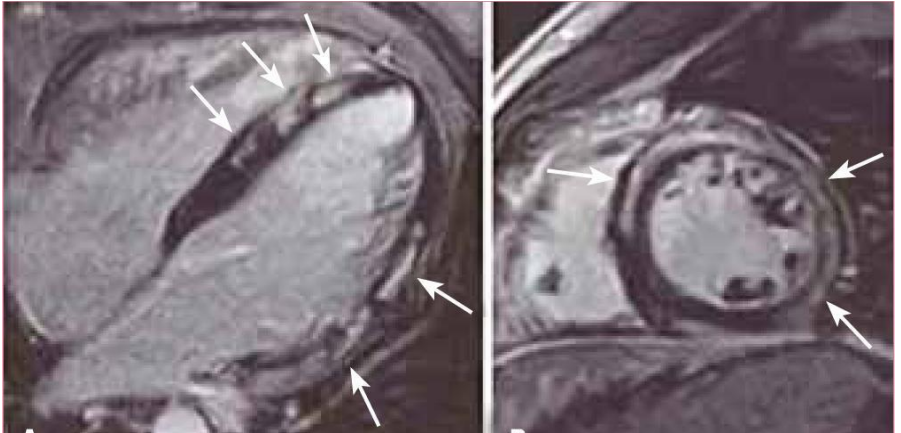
MRI scan of the heart. Areas of diffuse edema (inflammation of the myocardium) are indicated by arrows
